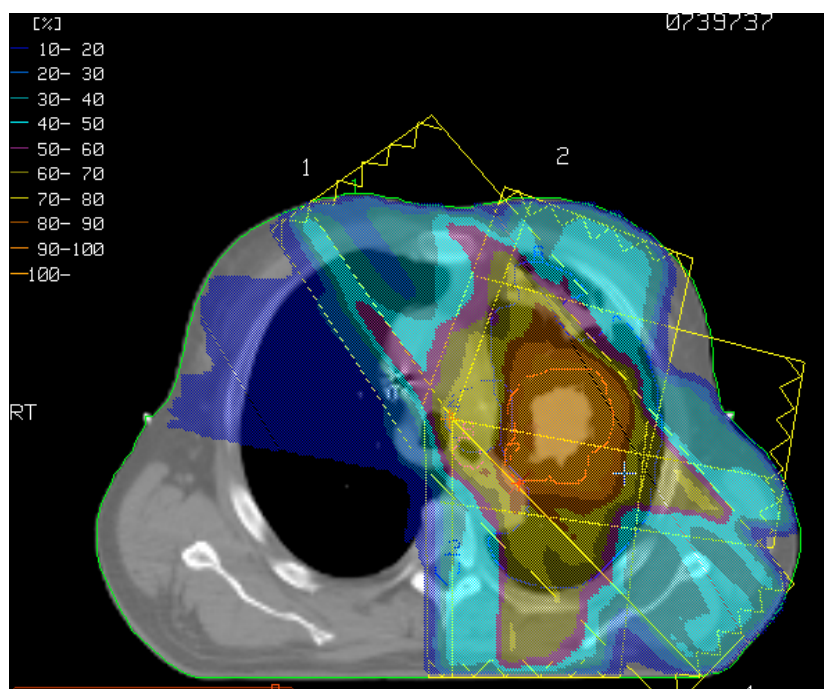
An axial CT slice and the dose distribution from the IMRT plan used in the measurement for patient A. The contour in red denotes the planning target volume. The measurement point was chosen to be near the centre of the tumour mass.
